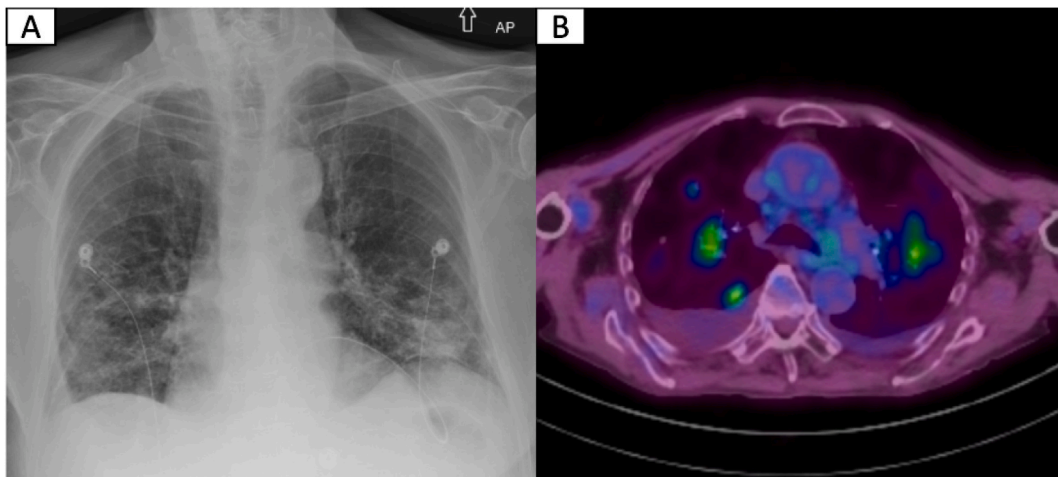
A: Chest X-ray upon discharge with radiographic improvement. B: PET scan with persistent hypermetabolic ground glass opacities and hilar lymphadenopathy.
